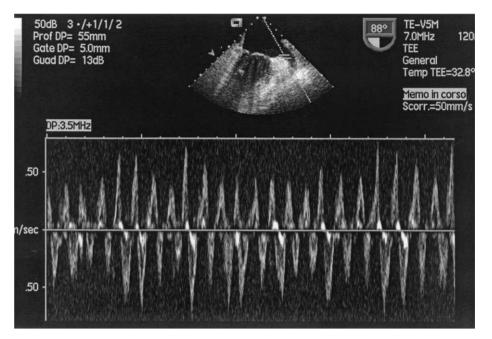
Pulsed Doppler tracing of the left atrial appendage (LAA) obtained by transesophageal echocardiography in atrial fibrillation showing high peak emptying flow velocity signals in a patient who preserved the sinus rhythm for one year. The mean LAA flow peak anterograde velocity was 52 cm/s.
